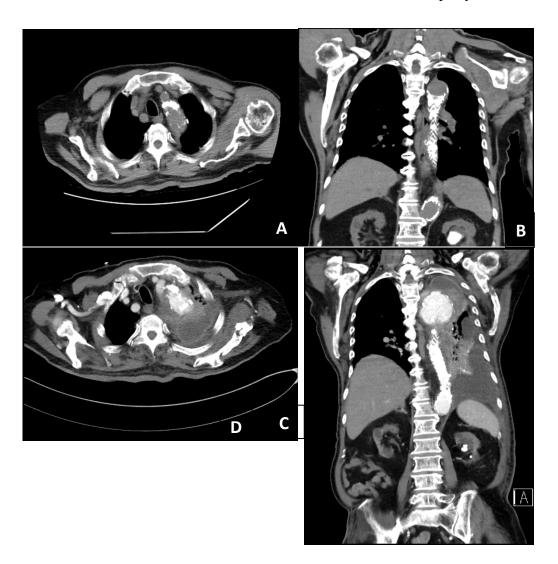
Representative computed tomography (CT) images of patient prior and upon diagnosis. The coronal section (A) and axial section (C) of non-contrast Chest CT of the patient on March 2019, 8 months prior to thoracic mycotic aneurysm diagnosis revealed previous repairment of the thoracic aorta aneurysm with stent in place. The coronal section (B) and axial section (D) of contrast Chest CT revealed markedly worsening of aneurysm in the aortic arch(8.3cm) with suspicion of rupture.
